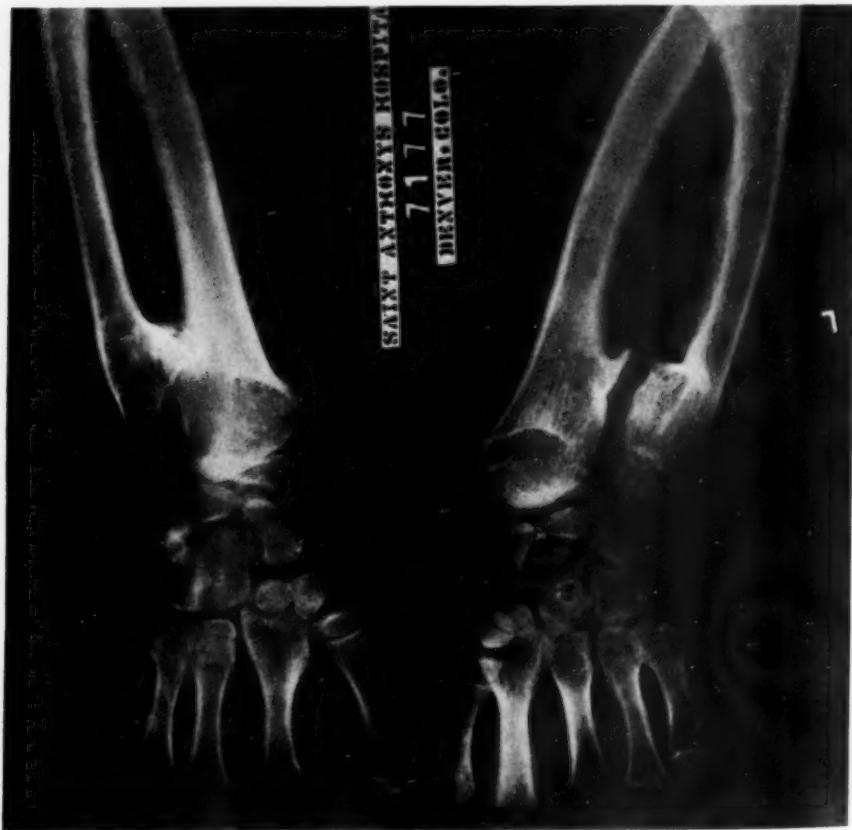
X-ray of forearms. Note shortening and bowing, and exostoses and enchondromata.
